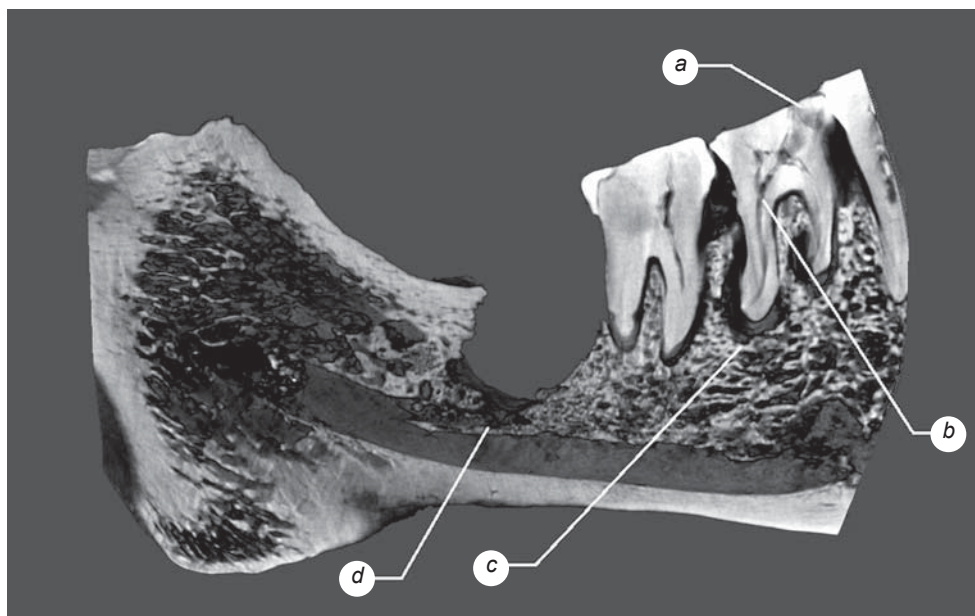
A CT image of the left side of the mandible.
